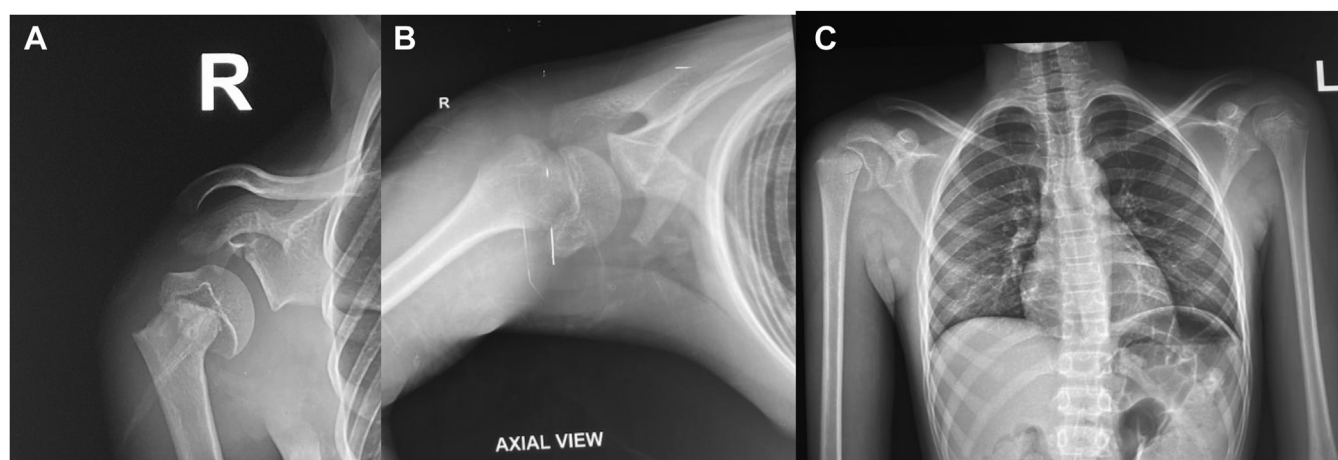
(A and B) Preoperative anteroposterior and axillary views of the X-ray show a displaced physal fracture of the right proximal humerus. (C) Right shoulder X-ray with the contralateral anteroposterior views.
